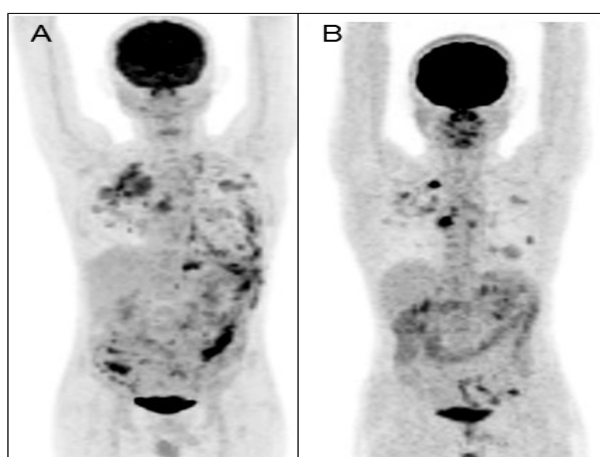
43-years old male gastric GIST, post surgical resection for the primary, underwent 18F-FDG-PET/CT for recurrence evaluation. 18F-FDG-PET/CT showed metabolically active pleural and peritoneal deposits, suggestive of metastatic disease (A). The patients was started on imatinib. Follow-up 18F-FDG-PET/CT after 4 weeks showed significant reduction in the extent and avidity of the lesions, suggestive of partial response (B).
